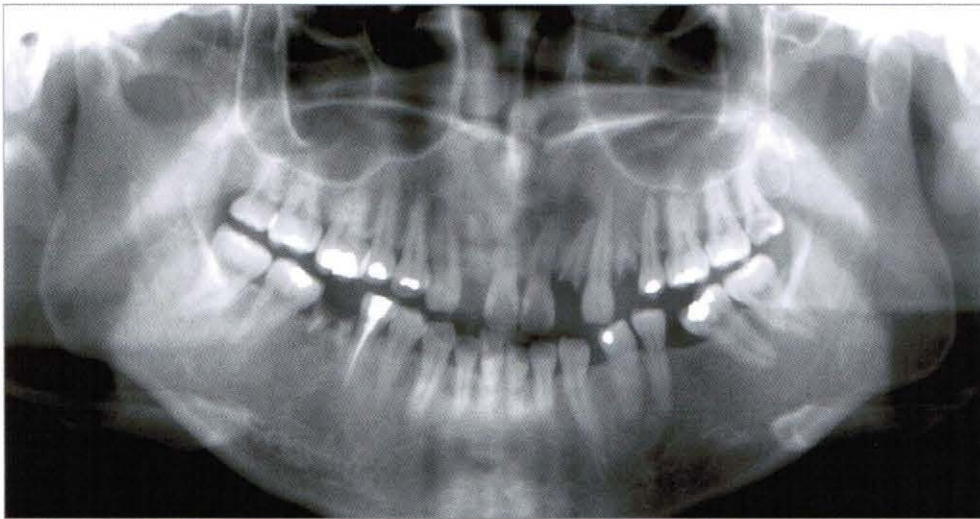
Panoramic radiograph on first visit to the Dental Hospital (2005, 12,8)
